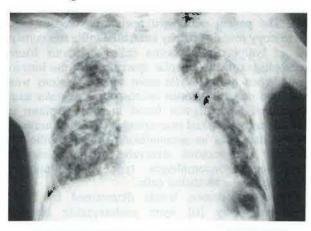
Chest X-ray showing diffuse interstitial infiltrates at first admission.
